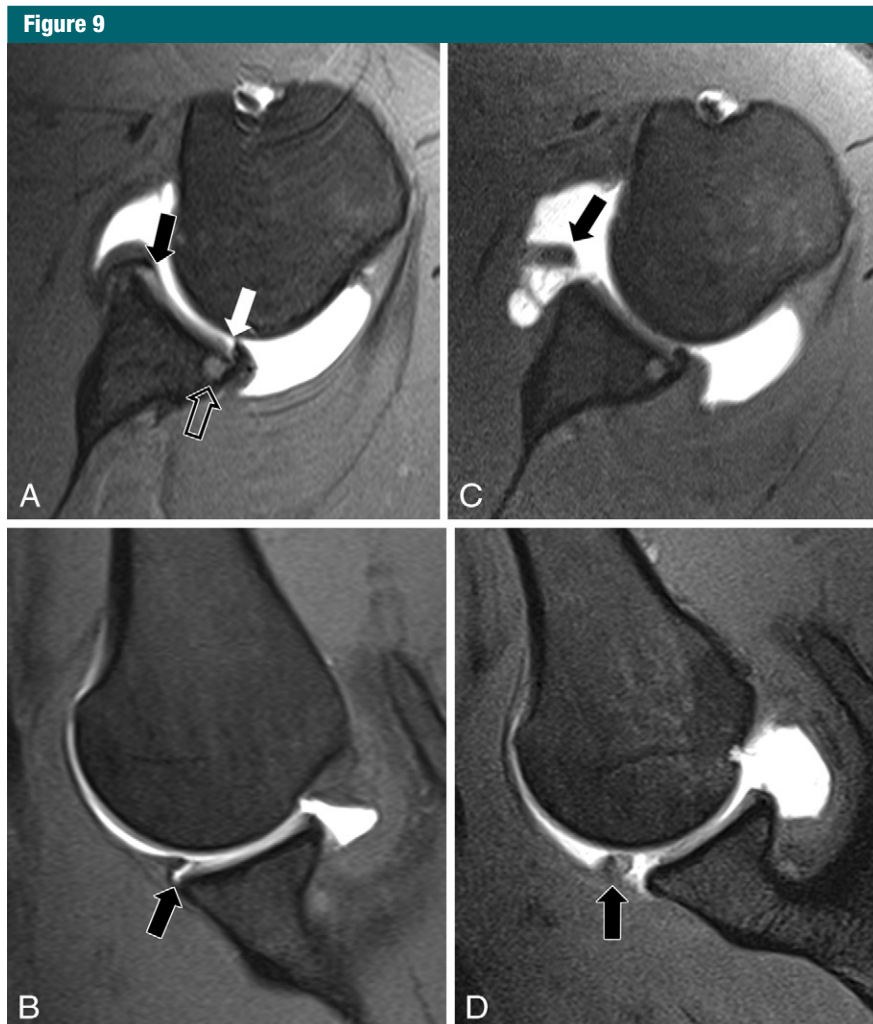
MR images in a 24-year-old extreme athlete who denied previous dislocation or major shoulder trauma. *A*, Axial, fat-suppressed T1-weighted MR arthrogram shows increased signal intensity at the labral chondral junction (black arrow), as well as a nondisplaced posteroinferior labral tear and a contrast agent-filled chondral defect with a GLAD lesion (white arrow). A small subchondral cyst is found adjacent to the posterior tear (open arrow). *B*, On ABER fat-suppressed T1-weighted MR arthrogram, tear of the anteroinferior labral chondral is made conspicuous (arrow). At the time of initial MR imaging, the patient elected to continue competition, forgoing surgical intervention. Repeat MR imaging 2.5 years later was performed due to disability preventing further competition. *C*, Axial fat-suppressed T1-weighted MR arthrogram shows a Bankart lesion and marked displacement of the anteroinferior labral-ligamentous complex (arrow) from the glenoid rim. *D*, ABER fat-suppressed T1-weighted MR arthrogram demonstrates progression to a GLAD injury in the anteroinferior labrum with detachment and displacement of a large labral chondral fragment (arrow). Arthroscopic stabilization procedure was performed. The posteroinferior labral chondral GLAD lesion appears to have healed in the interval.
